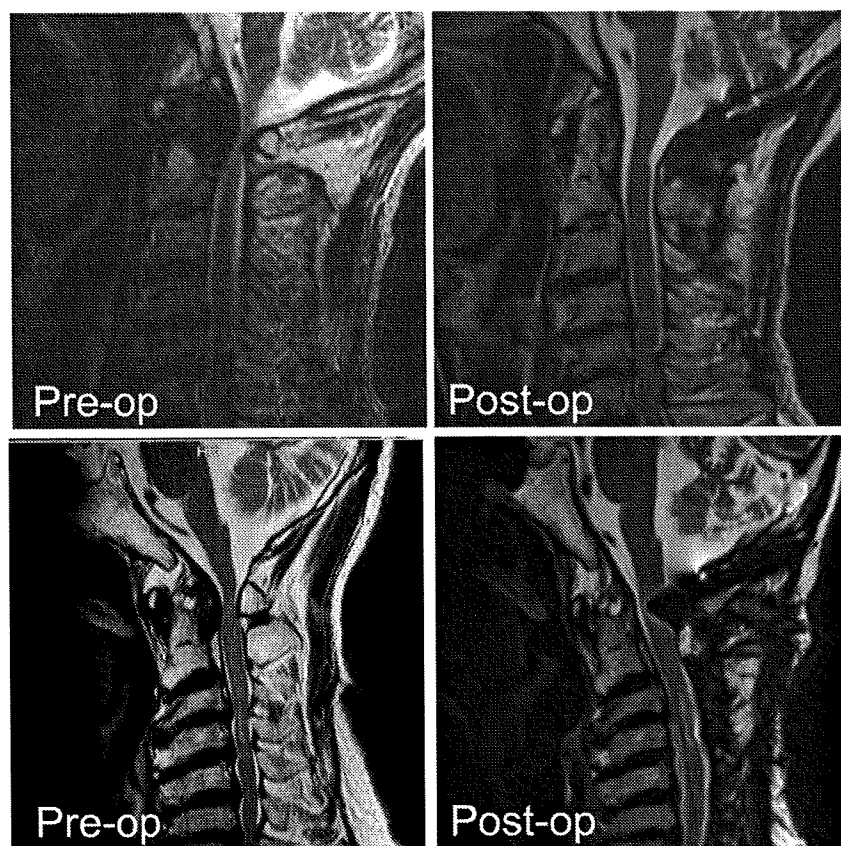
Preoperative and postoperative T2-weighted MR images of patient 8 (upper panels) and patient 6 (lower panels). Spontaneous regression of the mass lesion occurred after posterior fusion.
